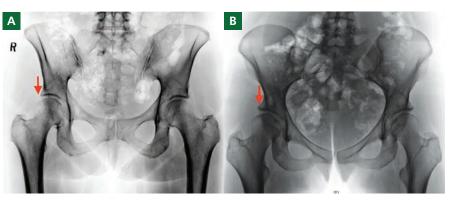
Anteroposterior radiographs of pelvis showing A, normal lateral joint coverage (see arrow) and B, dysplastic, decreased lateral joint coverage (see arrow).
